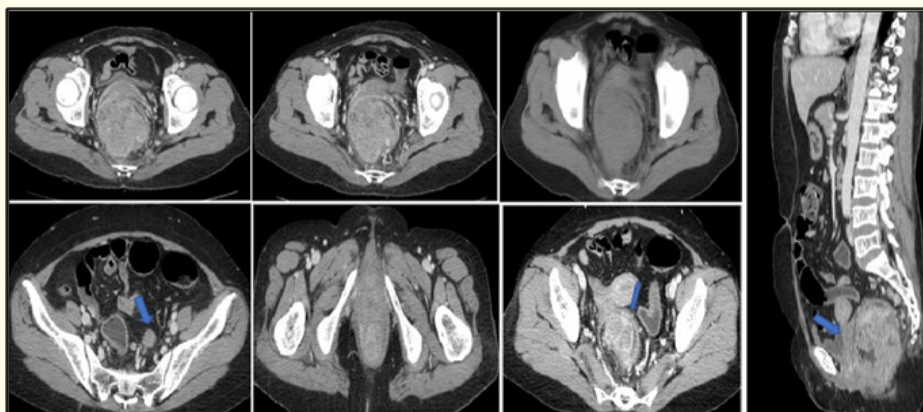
CT images of HPE proven Adenocarcinoma – Poorly differentiated. A: Axial venous phase shows a lobulated heterogeneously enhancing mass in the rectum causing widening of the rectum. B: Arterial phase shows vascular pedicle in posterior aspect arising from superior rectal artery. C: Plain CT image showing a soft tissue density mass. D: shows peri rectal lymph nodes E: shows extension of lesion to anal canal. F: shows perirectal fat stranding. G: shows the lesion extension to the cervix.
